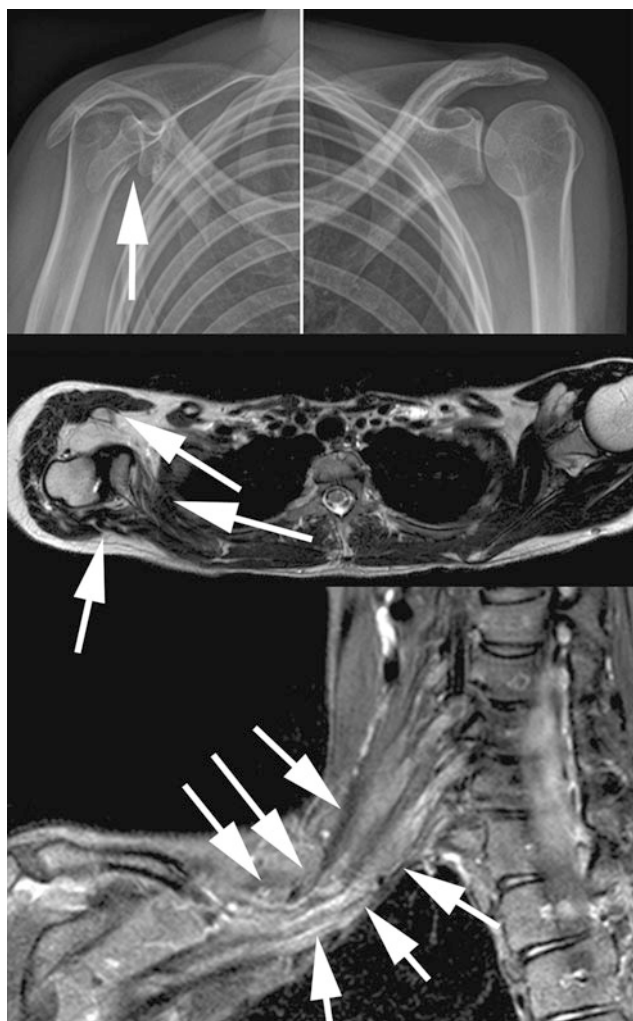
Radiographs (*upper row*), axial T2-weighted, and paracoronal STIR (short tau inversion recovery) sequences in a 23-year-old patient with perinatal brachial plexus injury. There is subluxation of the humeral head (*solid arrow in upper image*) and remodeling of the right shoulder, typical for a glenohumeral deformity. Please note the significant atrophy of the subscapular and infraspinatus as well as right sided deltoid muscles (*solid arrows in middle image*). The paracoronal STIR image depicts extensive traction neuromas of the upper and middle trunk (*solid arrows in lower image*)
